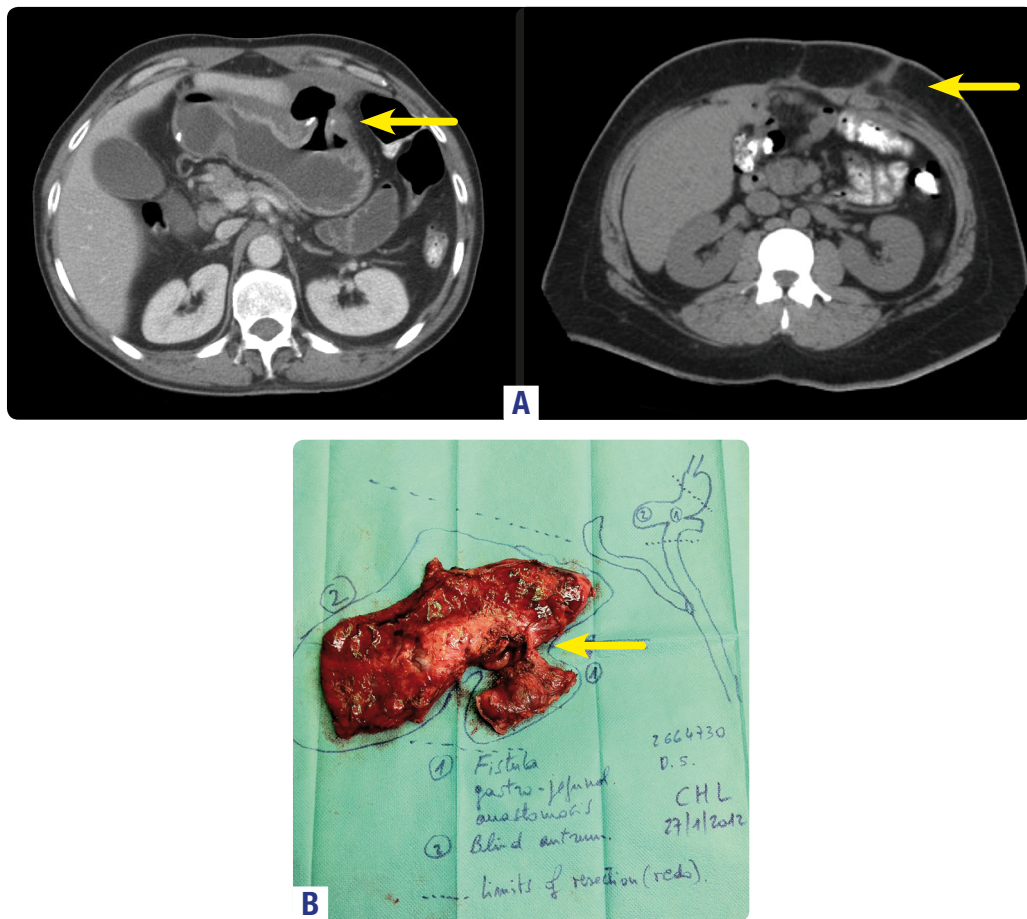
A: Chronic GJAL with enterocutaneous fistule appears in CT scan with oral contrast. B: While definitive laparoscopic surgery, insufficient gastric resection after a duodenal ulcer was found out to be the reason for the leak.
